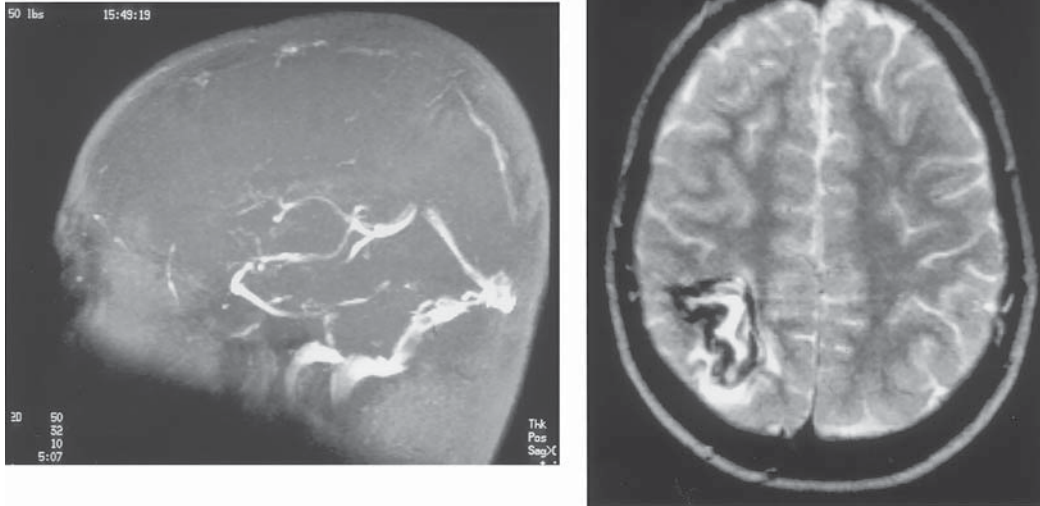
MRI showing the typical posteriorly located hemorrhagic infarct associated with superior sagittal sinus thrombosis (right). An MRV confirmed the thrombosis on this patient being treated with L-Asparaginase (left).
